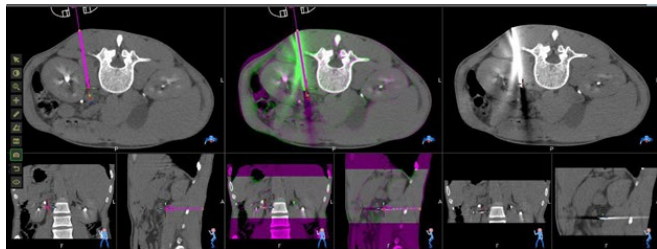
Robotic-assisted CT-guided biopsy of a para-aortic lesion demonstrating trajectory planning and needle confirmation.
